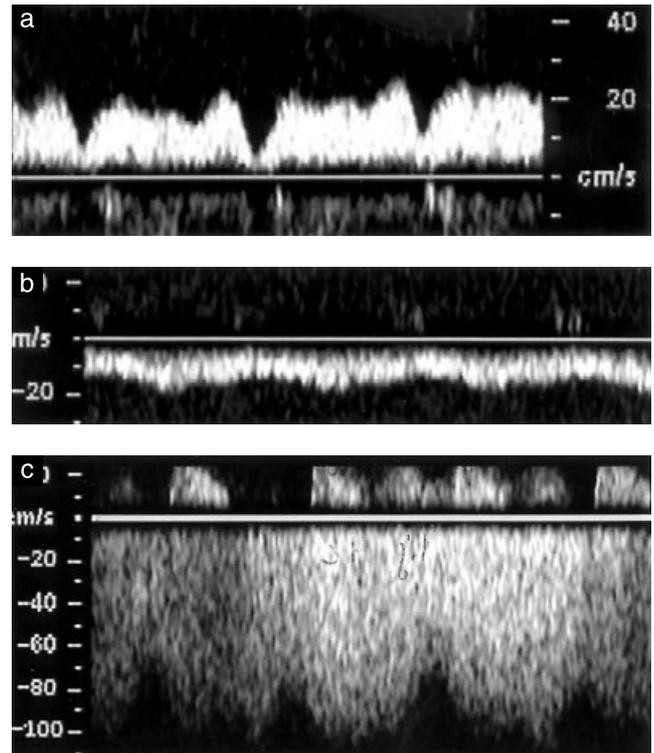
(a) Doppler waveform from a normal pulmonary vein in the fetus. There is biphasic flow with a systolic and diastolic peak. Very little or no forward flow is seen at the end of diastole. (b) Doppler waveform from a pulmonary vein upstream from a stenosis (Case 15). There is continuous monophasic flow with low velocity. (c) Doppler waveform from the vertical vein downstream from the stenosis (Case 7). There is continuous forward flow with increased velocity.
